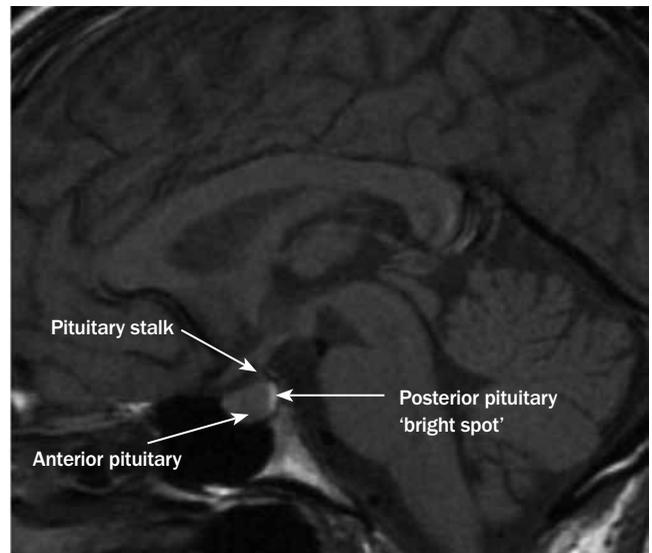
MRI of a normal pituitary gland (T1 image).
